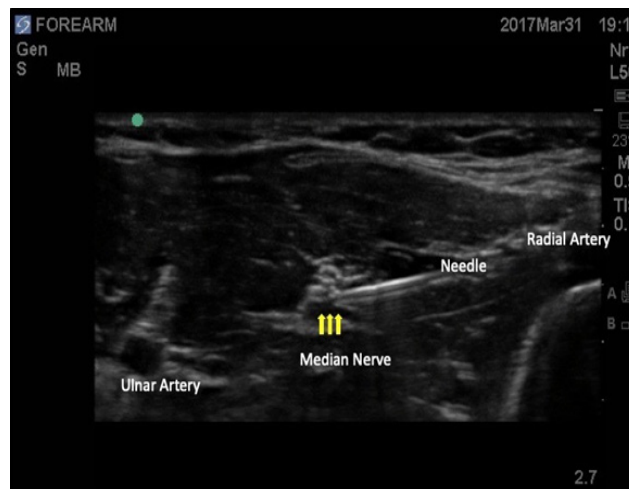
Image shows the median nerve block performed under ultrasound guidance at the level of elbow.
